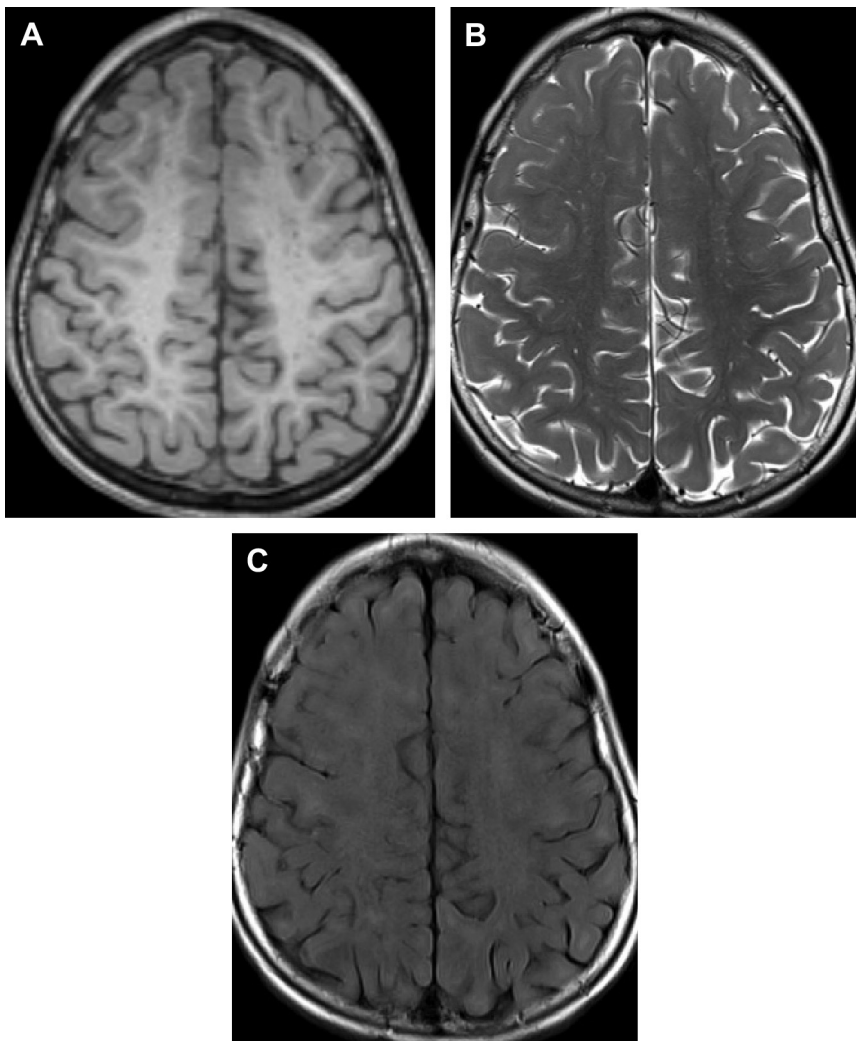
Eight-year-old girl with galactosemia. Although the axial T1-weighted images suggest normal myelination (A), there is poor gray-white matter differentiation on the axial T2-weighted images (B) suggesting diffuse poor myelination of the subcortical white matter. These signal abnormalities are more conspicuous on the axial fluid attenuated inversion recovery images (C) where there is patchy signal increase.
